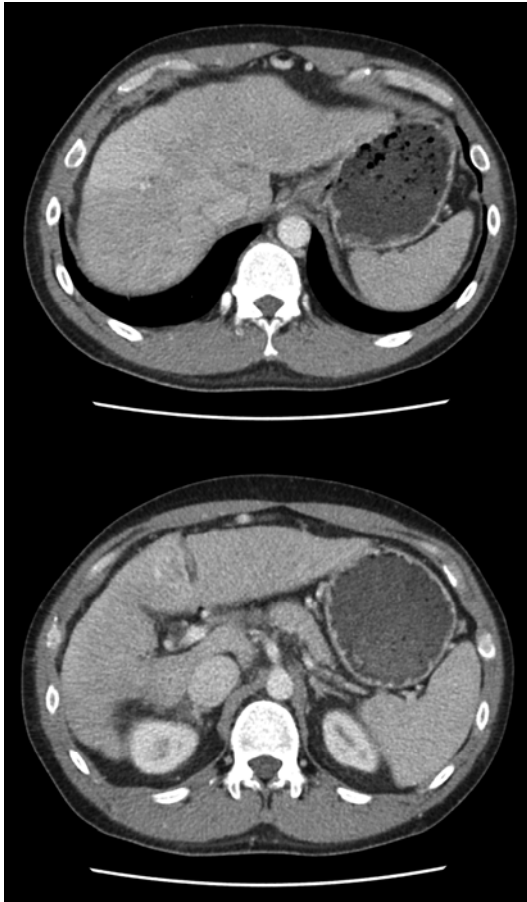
Preoperative CT scan showing patent portal vein and absence of significant portosystemic shunting.
